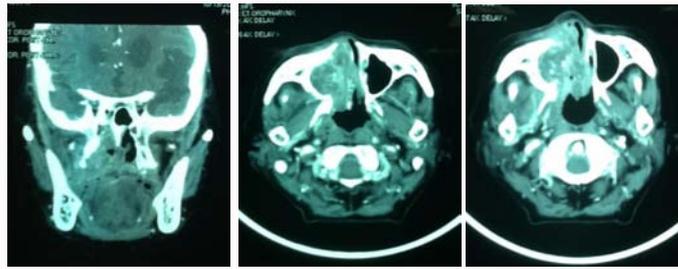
Show CT scan paranasal sinus coronal and axial view.
